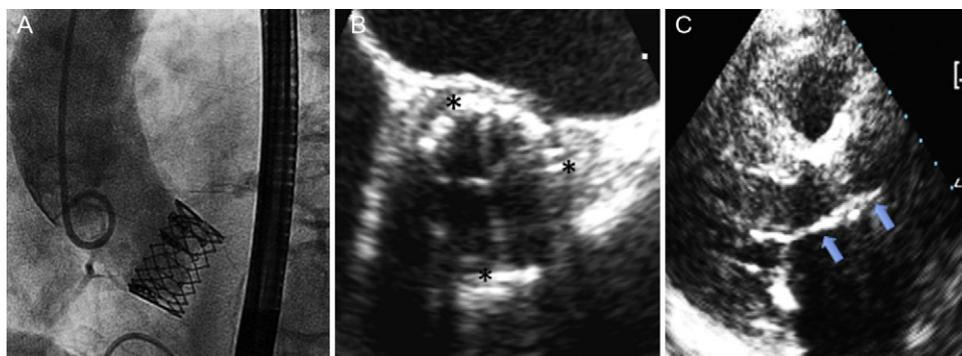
Images following implantation. A: aortogram, with adequate deployment and without aortic regurgitation. B: short-axis perioperative transesophageal echocardiography at the level of the aortic valve plane, with adequate prosthesis expansion (asterisks indicate the valve outline). C: long-axis parasternal follow-up transthoracic echocardiography, with adequate prosthesis implantation (arrows indicate the site of valve implantation).
